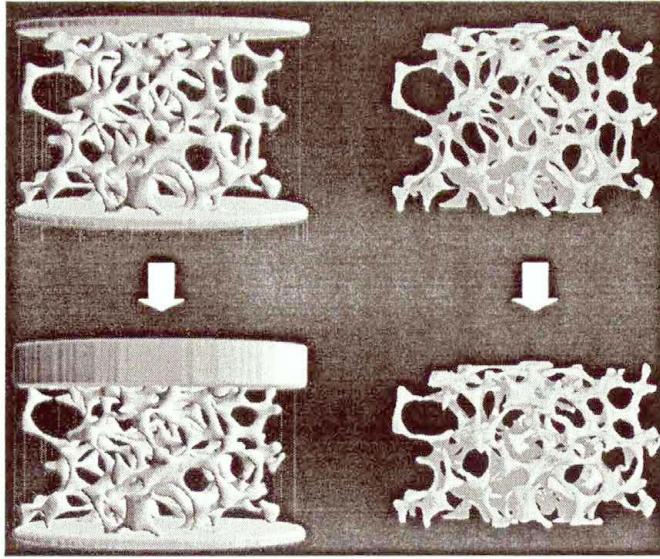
Compression of trabecular foam sample. Left: μ CT recording during compression. Right: FE model replicating experimental compression sequence (FE images courtesy Dr. Mark Taylor, University of Southampton).
